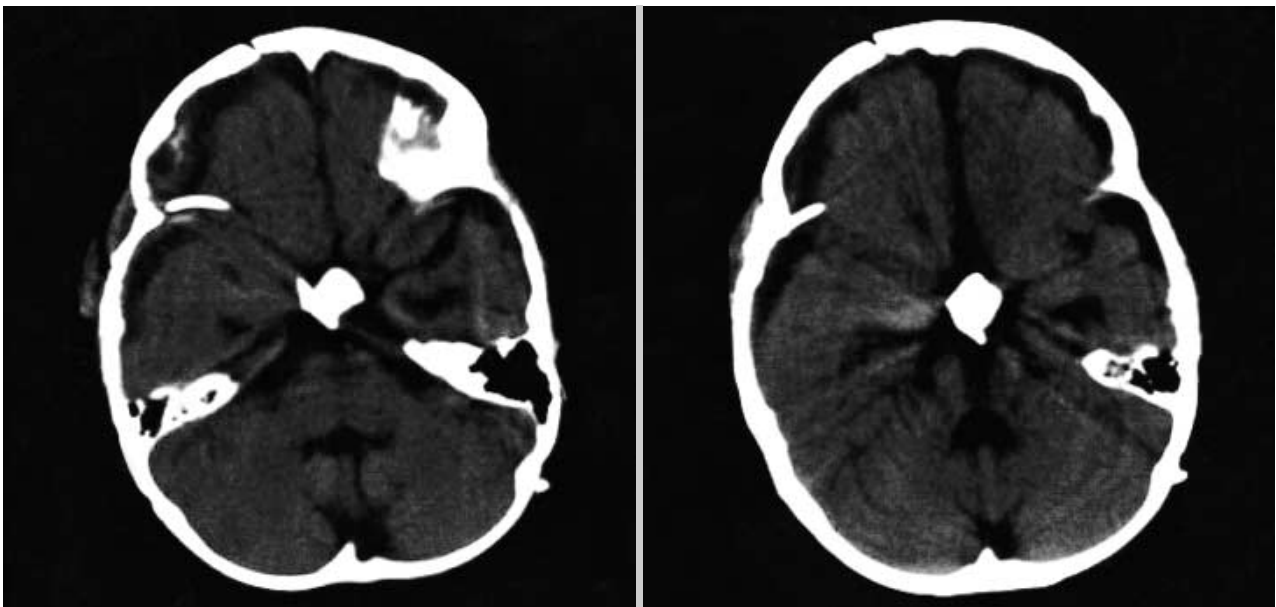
Brain CT taken 20 months after a partial tumor removal and postoperative intracavitary bleomycin injection in Patient No. 10.
